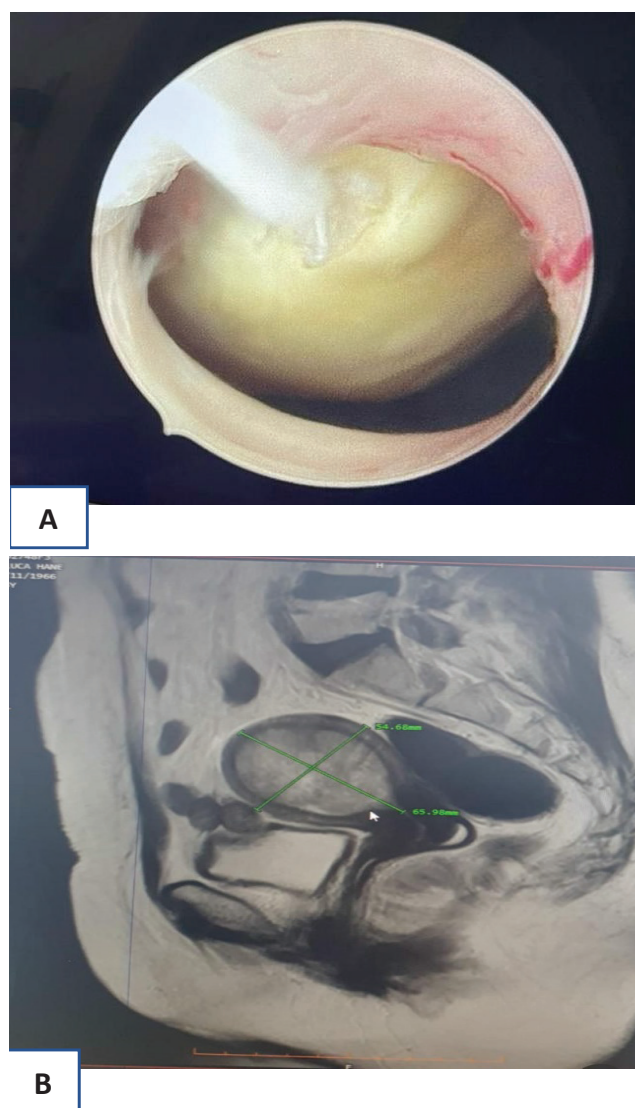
A) Hysteroscopy image B) The MRI imaging
